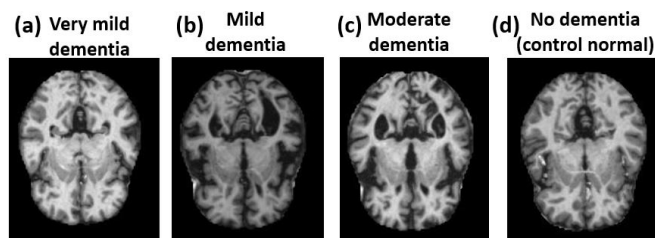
Example of Kaggle MRI images at various stages. (a) Very mild dementia (b) Mild dementia (c) Moderate dementia and (d) No dementia (control normal).
